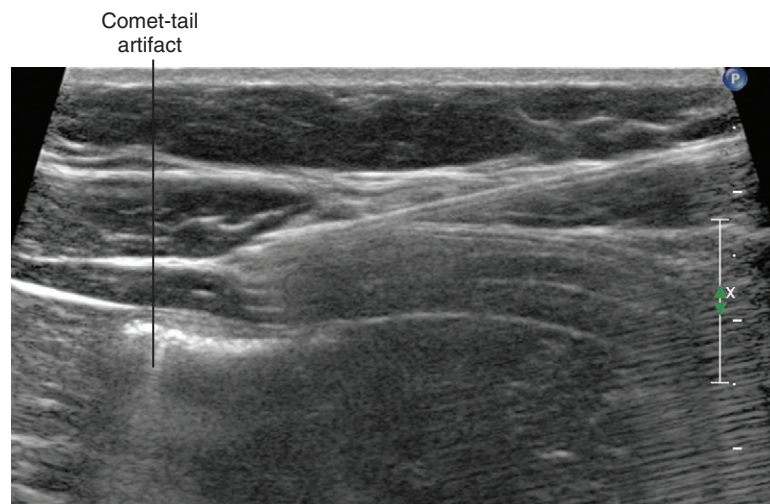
Comet-tail artifact from the peritoneum during rectus sheath block. The peritoneum and pleura have similar appearances on ultrasound scans.
